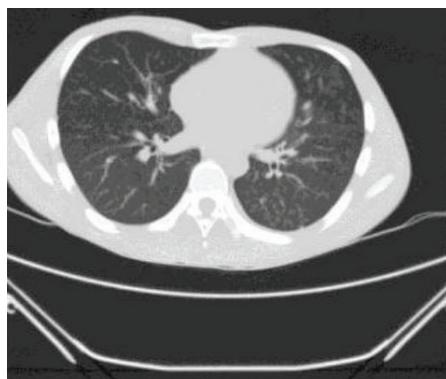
CT showing resolution of Pneumomediastinum
